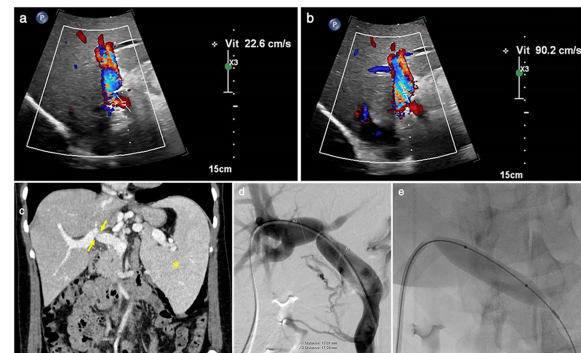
Focal stenosis of 2 mm long of the portal trunk before bifurcation: normal portal flow (22.6 cm/s) upstream the stenosis (a) vs accelerated flow (90.2 cm/s) downstream the stenosis (b); computed tomography, portal phase, axial section with portal vein kinking (arrows) and signs of portal hypertension, for example, splenomegaly (*) (c); portal vein catheterism and angiography (d) and balloon dilatation of the stenosis (e).
